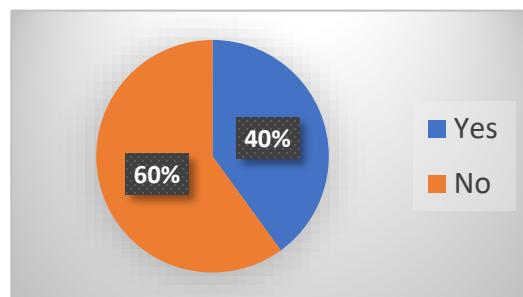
Does your office screen all DWI defendants?
